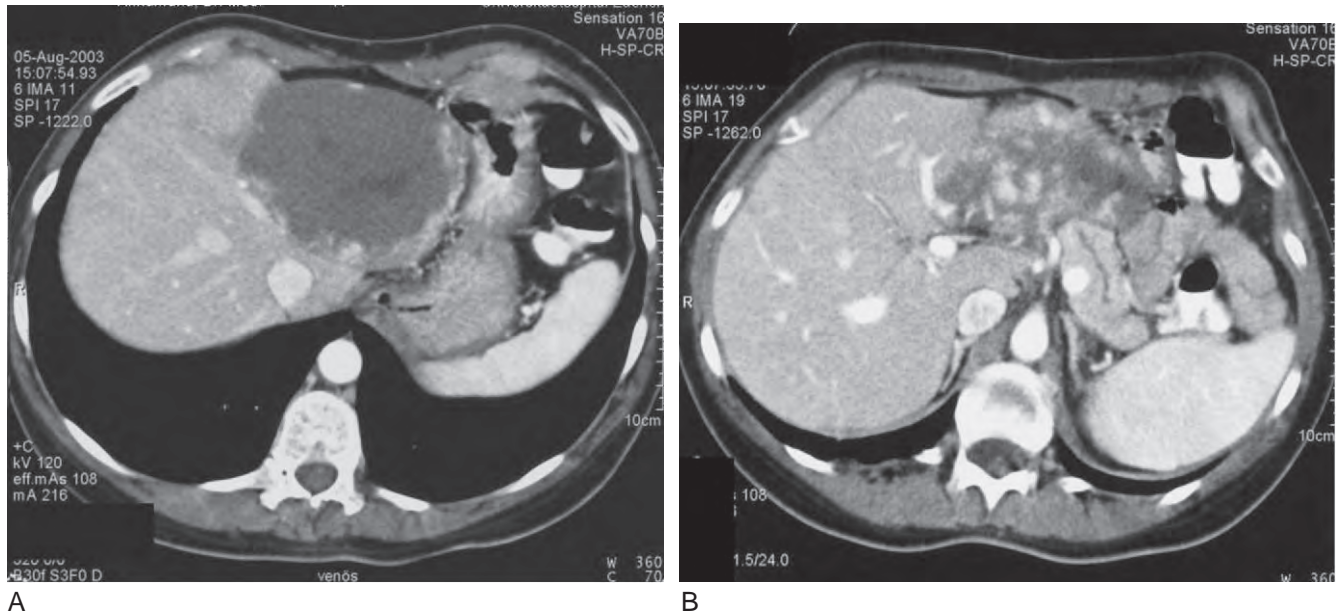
Contrast-enhanced CT of large hemangioma in the left hemi-liver displaying hypoattenuation on early scans (A) and centripetal filling on delayed images (B).
